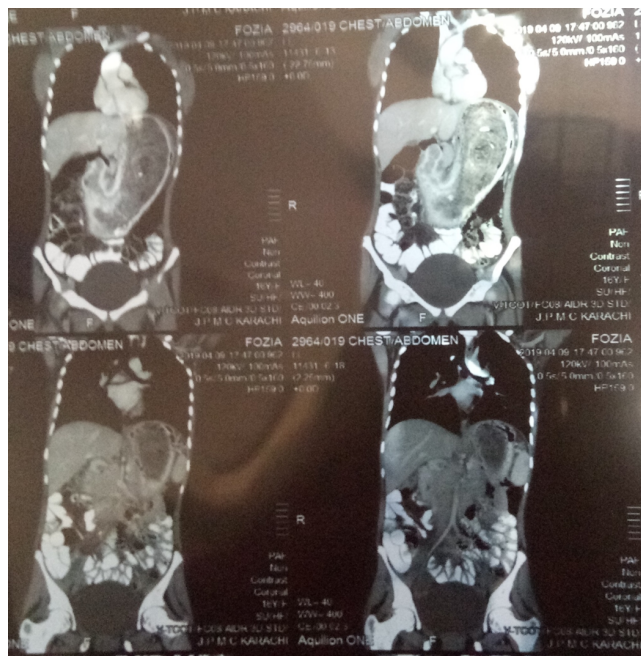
CT scan showing large bezoar in stomach with extension into duodenum.
